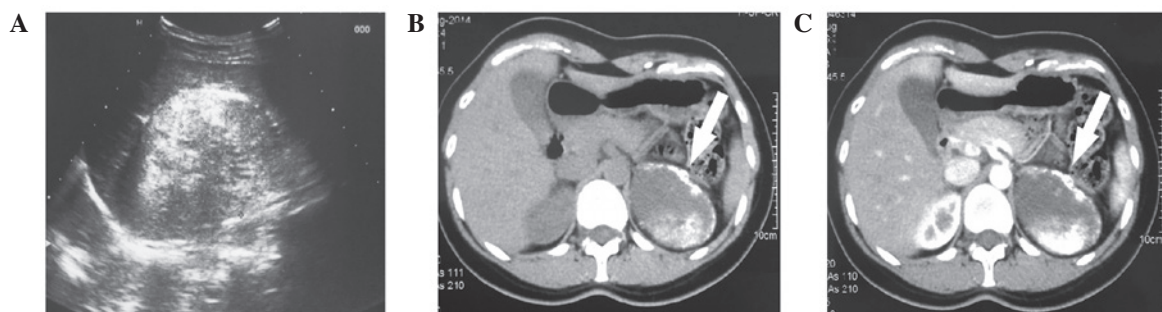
Imaging features of an adrenal teratoma from one case. (A) Ultrasonography showing a mixed echo. (B) Computed tomography revealing a mass with mixed density and calcifications in the left adrenal region, as indicated by the white arrow. (C) Mildly enhanced mass.
